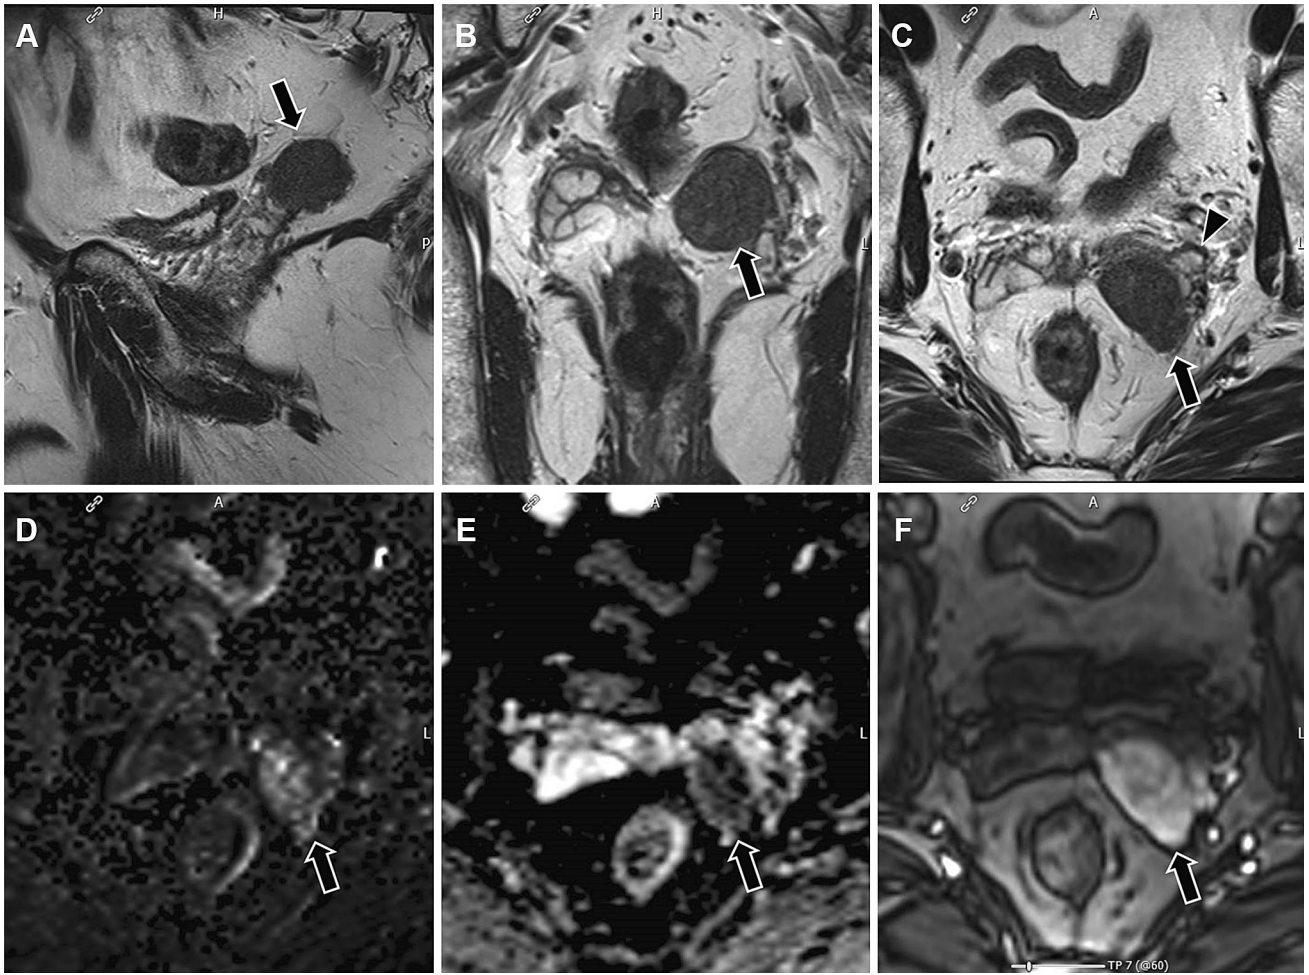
Sagittal (A), coronal (B), and axial (C) T2-weighted images demonstrate a well-circumscribed lobular mass (arrow) with intermediate to low signal intensity abutting the left seminal vesicle (arrow head, C). The mass has high signal intensity on diffusion-weighted image (arrow, D) and low
